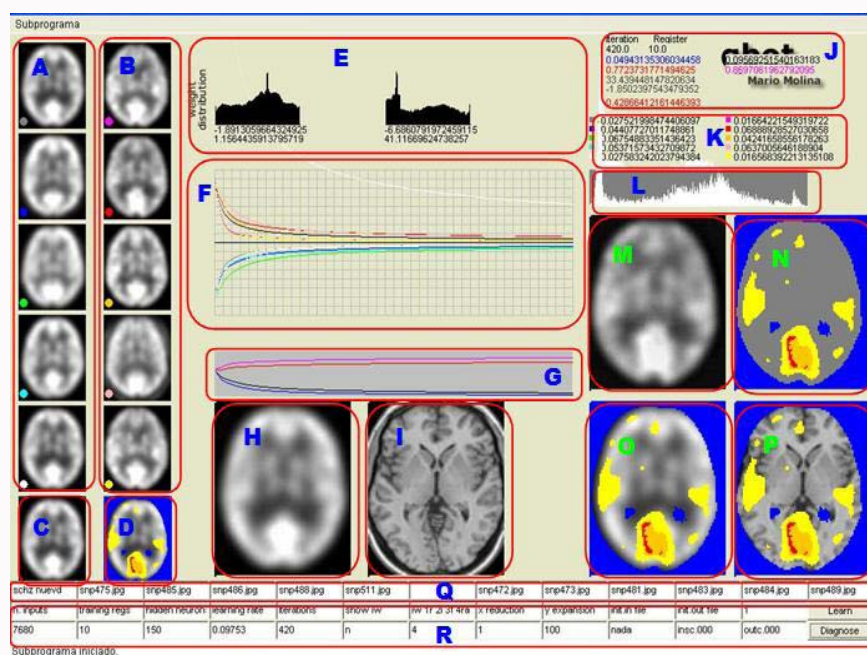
The developed algorithm: Qbot. Compare area F of this figure with Figure 3. The system detects the characteristic metabolic patterns of the disorder and the error curves converge to 0, which indicates that the algorithm can find specific activation patterns in the analyzed images. A and B: Training PET images, level 0 (Talairach, 1988). C and D: First patient to diagnose. E: Final histogram of the weighted topographic image. F: Relative Errors of the algorithm. G: Diagnostics area. H: First patient to diagnose amplified. I: MRI reference. J, K and L: Learning process, numeric evolution, real time. L: histogram of the weighted topographic image, real time. M: weighted topographic image. N, O, and P: Auxiliary images, superimposed.
